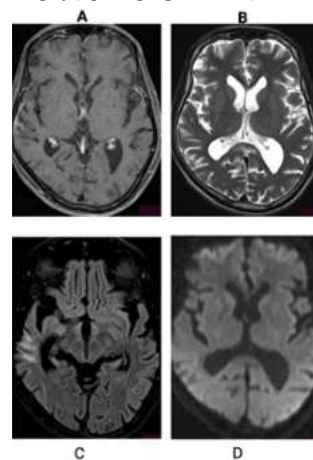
Meningitis- FLAIR hyperintense areas (C) noted along sulcal spaces of right temporal lobe showing no diffusion restriction on DWI(D), on T1 post contrast study (A) there is abnormal post contrast enhancement along sulcal spaces of right temporal lobe. CSF along sulcal spaces of right temporal lobe appears slightly hypointense on
